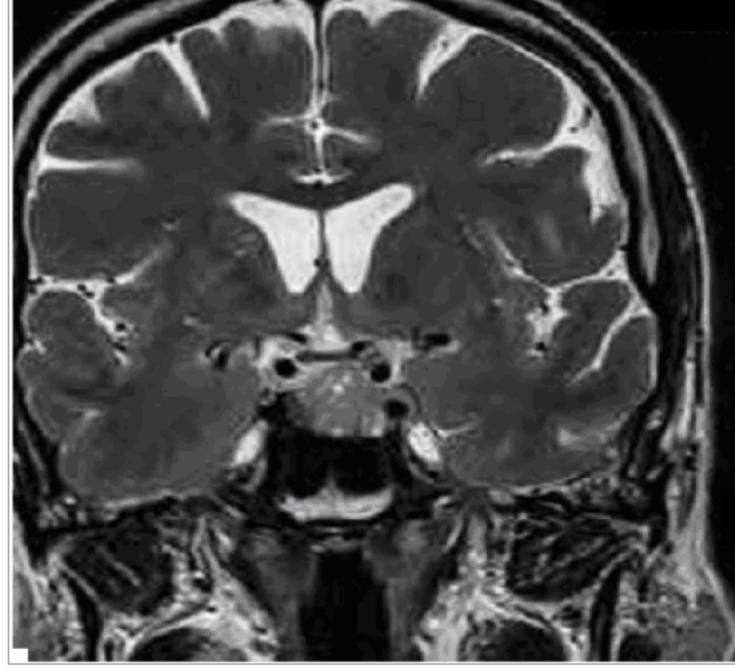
Pituitary MRI revealed an intrasellar lesion measuring 15X17mm with T2 hyperintense, T1 hypointense aspect and increased signal after gadolinium infusion compatible with pituitary adenoma.
